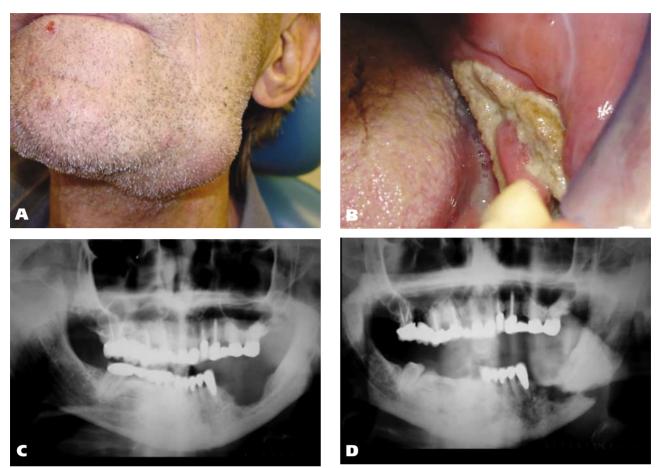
Patient with multiple myeloma who used pamidronate and zoledronic acid for at least four years came to the emergency clinic with severe swelling and pain on the left mandible (A). Palpation of the area suggested a fracture. Intraoral examination revealed an extensive area of osteonecrosis (B) and the panoramic radiograph (C) confirmed a pathological fracture. Observe the progression of the osteonecrosis to fracture in six months. The fracture was surgically stabilized. The presence of a plamacytoma was confirmed in the area (D). The patient now is receiving hyperbaric oxygen therapy in preparation for radiation therapy. Photos reproduced with permission of Dr. Steven I. Kaltman, Nova Southeastern University, Fort Lauderdale, Fla.
